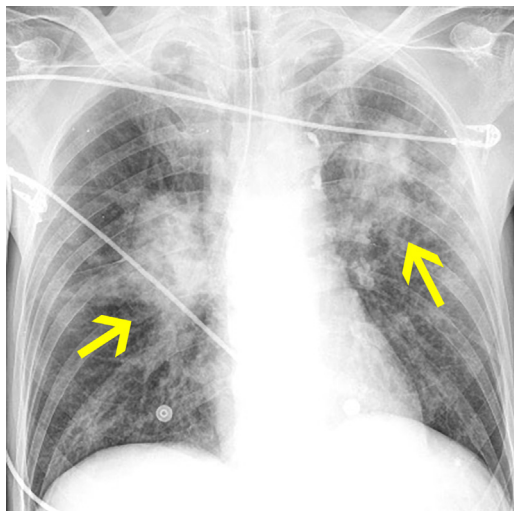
Pseudomonas* pneumonia. Portable chest radiograph shows extensive bilateral poorly defined areas of consolidation in the upper lobes (arrows).
